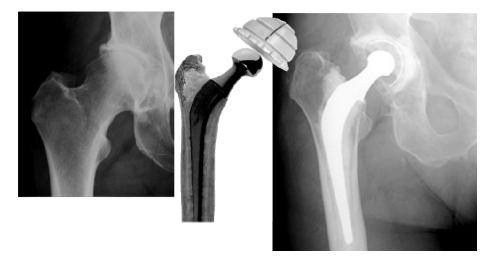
X-rays of an osteoarthritic hip joint (left), a photo of a cemented Charnley hip prosthesis with plastic acetabular cup (middle), and x-ray of a similar total hip prosthesis after hip replacement (right).
